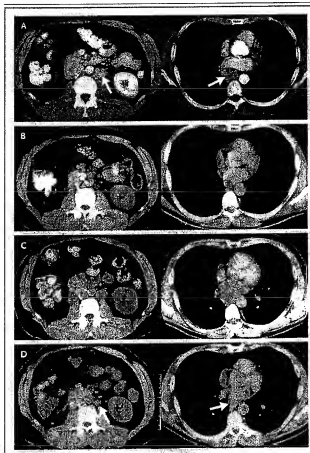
Serial Radiographs of a Patient Treated with High-Dose Bevacizumab. Panel A shows the pretreatment assessment (arrows indicate lymph-node metastases). Panel B shows a radiograph obtained two years later, when treatment was stopped during a partial response. Panel C shows relapse of tumor six months thereafter. Panel D shows a second partial response 3 months after therapy was restarted, which is ongoing at more than 18 months as of this writing.
